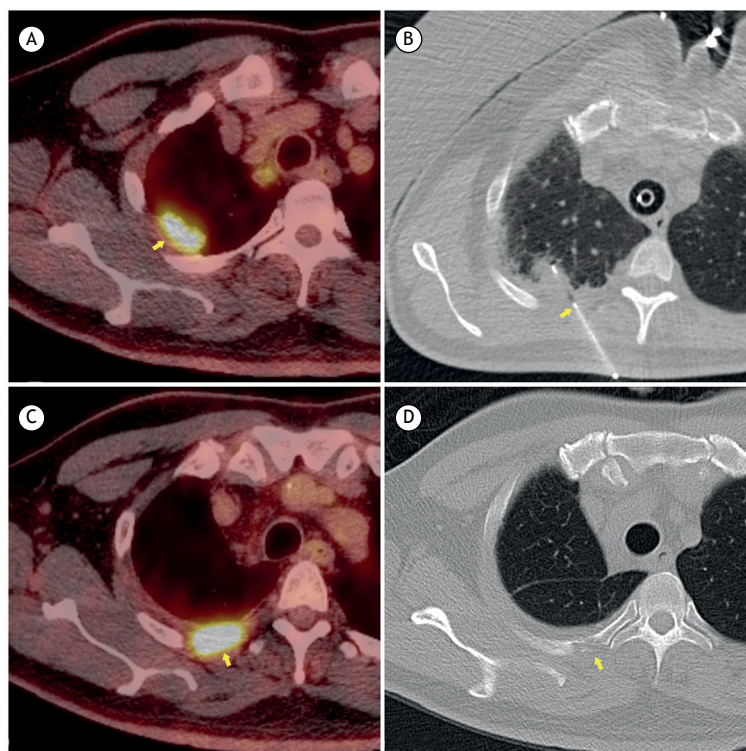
Nodule in the right lung apex and percutaneous biopsy of the same: in A, positron emission tomography-CT (PET-CT) scan showing the nodule (arrow); in B, CT scan showing the point of insertion of the coaxial needle (arrow); in C, PET-CT scan after 6 months of follow-up, showing an ^{18}F -fluorodeoxyglucose-avid soft tissue mass; and in D, CT scan after 6 months of follow-up, showing bone erosion of the right third rib posteriorly (arrow).
